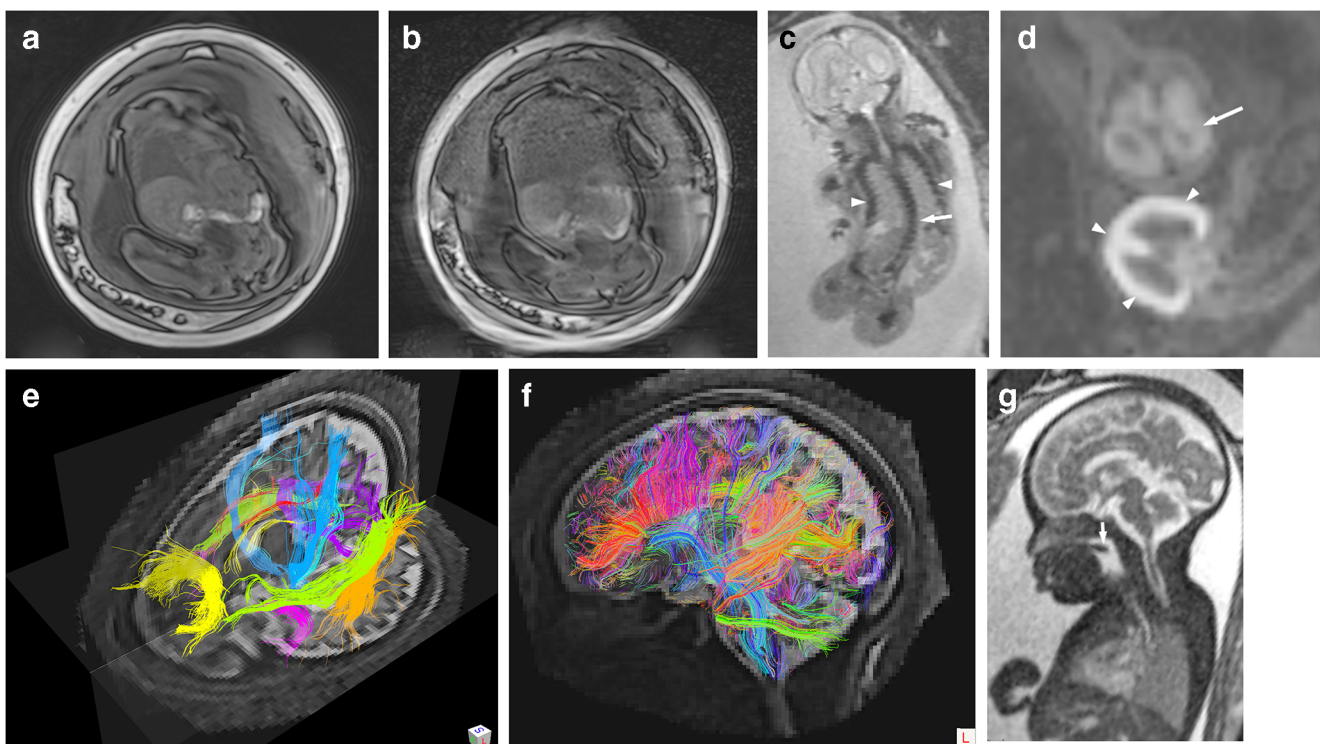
Fetal MR sequences. a, b T1-weighted images are fundamental in evaluating the fetus. The thyroid, liver and meconium are T1 hyperintense in the normal fetus. T1-weighting also aids in evaluating for hemorrhage. Acquiring T1-W images benefits from maternal breath-hold, as demonstrated in these coronal images of the same 34-week fetus with (a) and without (b) breath-hold. Note the sharper borders and anatomy seen with breath-holding. c Coronal echoplanar imaging (EPI) shows a 22-week fetus with congenital musculoskeletal scoliosis (*arrow*) and bell-shape thorax (*arrowheads*). d Axial diffusion-weighted imaging (DWI) of the brains of these 19-week twins with twin–twin transfusion
